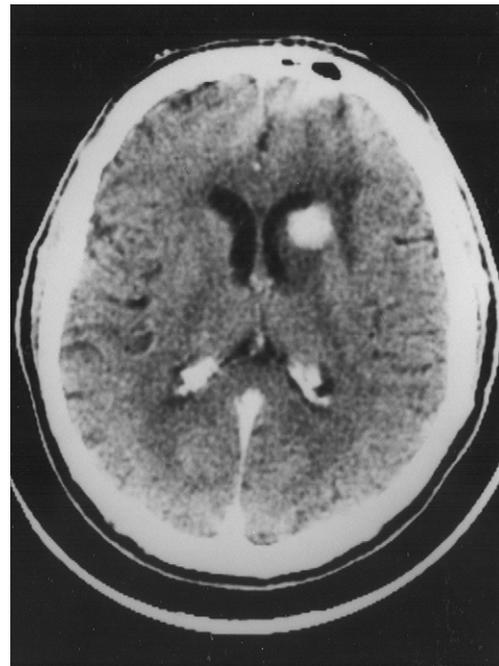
Cerebral blastomycosis in a 22-year-old man with a 1-week history of headache. CT scan shows an enhancing lesion adjacent to the left frontal horn; there is surrounding low-density edema.
